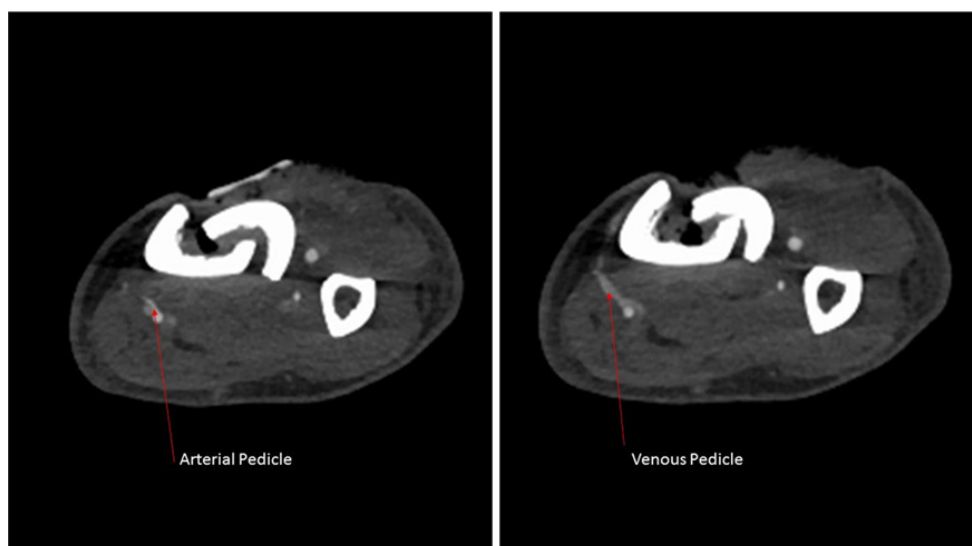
Computed tomographic angiography imaging of traumatized extremity with identification of potential recipient vessel prior to planned perforator flap for anterior tibial soft tissue
